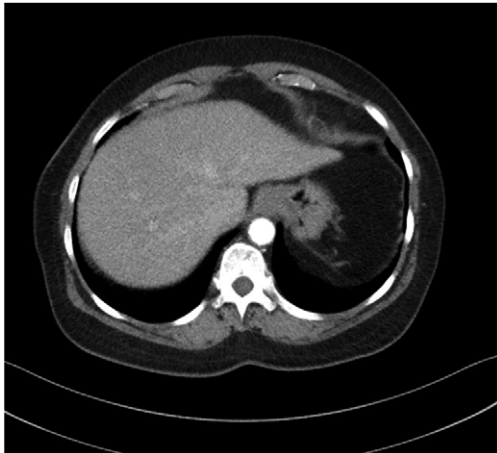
CT scan: no spleen can be detected in the left upper quadrant of the abdomen.
